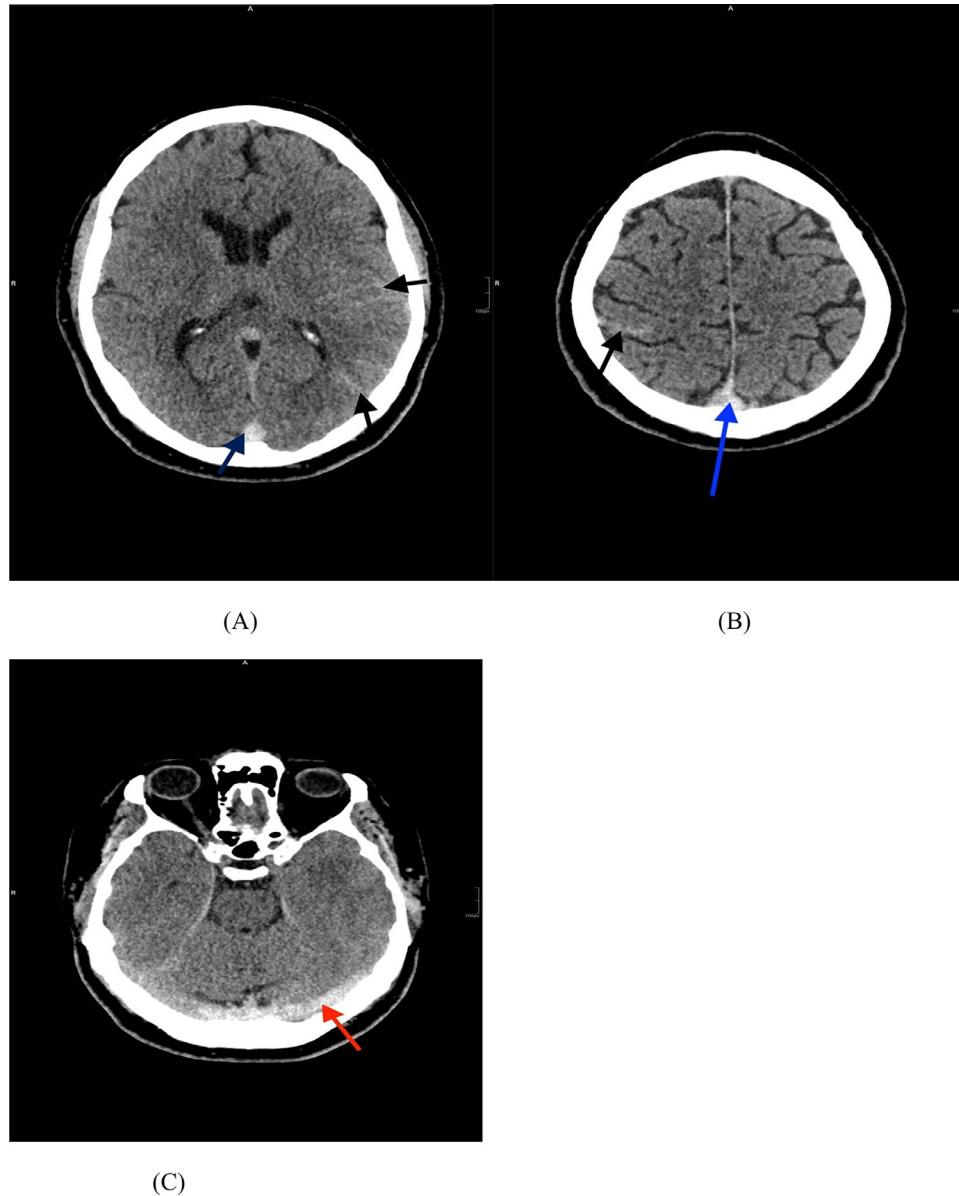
Noncontrast CT head (A and B) revealed: bilateral subarachnoid hemorrhage predominantly in the left temporoparietal region and, to a lesser extent, in the right high parietal lobes (black arrows) and bilateral subarachnoid hemorrhage predominantly in the left temporoparietal region and, to a lesser extent, in the right parietal lobe. Hyperdense superior sagittal sinus raising concerns of underlying venous thrombosis (blue arrows). (C) Left transverse sinus appeared hyperdense denoting thrombosis (red arrow).
